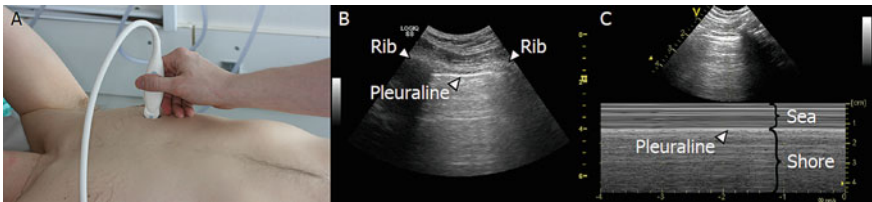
Normal lung ultrasonography findings: a The transducer is placed in a longitudinal axis over an intercostal space at the anterior surface of the chest. b In the corresponding B-mode image, two ribs are visible aligning the intercostal space, as two hyper-echoic lines with an underlying shadow. Lying deeper between the two ribs, a hyper-echoic horizontal line is seen representing the visceral and parietal pleura. Using B-mode the movement of the pleural line is called “lung sliding”. c If M-mode scanning is applied, a characteristic pattern called “seashore sign” is visible. The pleural line appears as a hyper-echoic line, with the more superficially placed structures appearing as horizontal lines similar to the sea and the part of the picture below the pleural line is grittier looking, mimicking the sand on a seashore (Courtesy The Scandinavian Airway Management Course, Airwaymanagement.dk)
